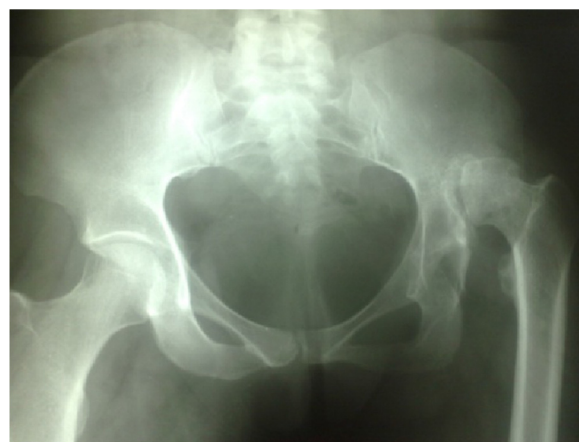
Radiography of pelvis in the anteroposterior view in the preoperative planning that highlights the developmental dysplasia of the left hip with stubborn dislocation.
